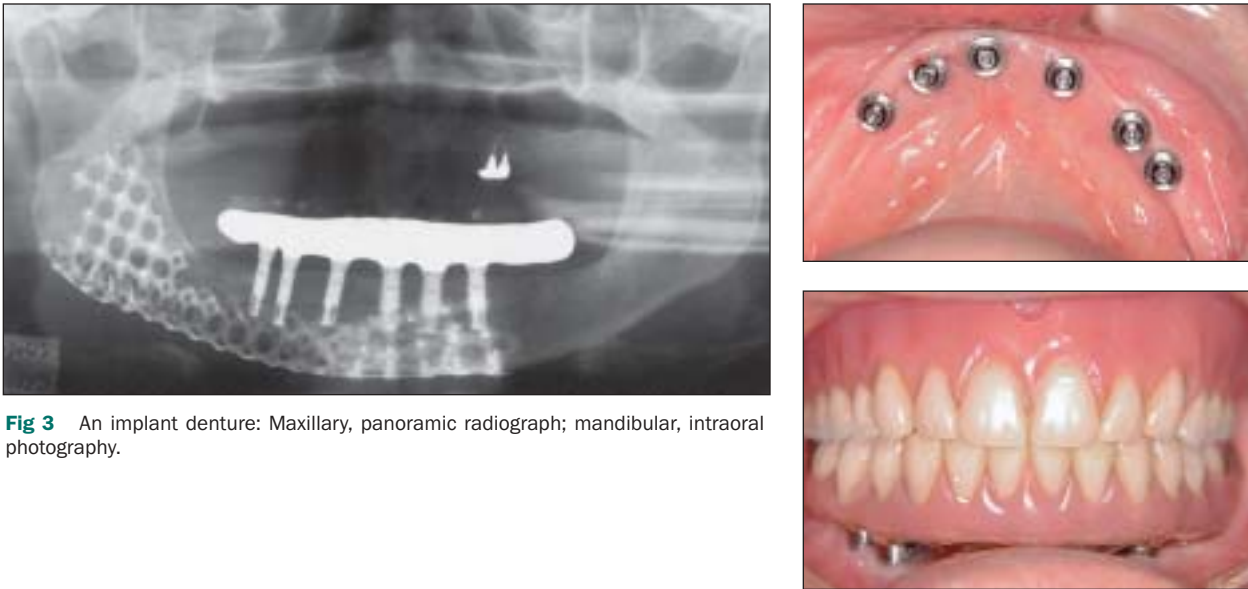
An implant denture: Maxillary, panoramic radiograph; mandibular, intraoral photography.
